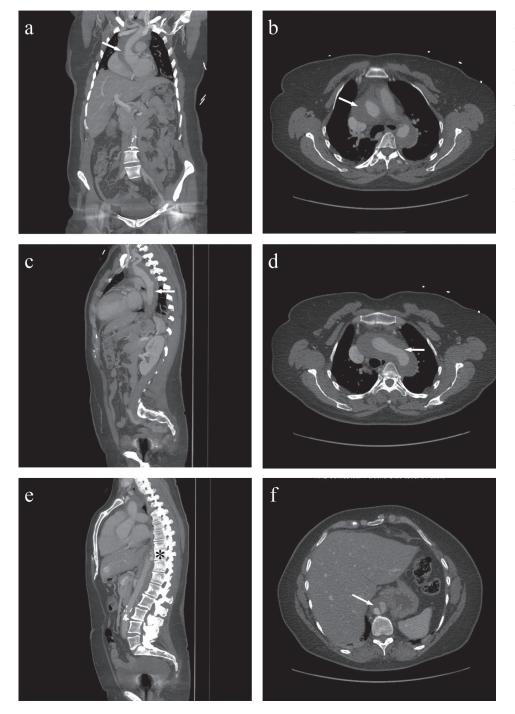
CT aortogram with contrast showing type A aortic dissection. a) Coronal image showing dissection in the aortic root and ascending aorta, b), c) and d) Dissection in the ascending aorta, thoracic descending aorta, and aortic arch, e) Sagittal section showing dissection in the abdominal descending aorta with blood in the false lumen (*), f) Axial section showing dissection in the abdominal descending aorta with an intimal flap (arrow)
